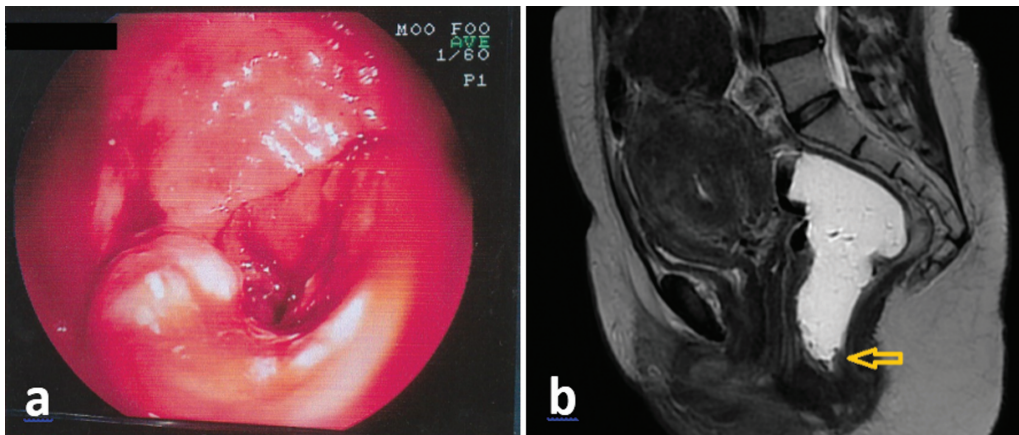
(a) Rectal tumor endoscopic view. (b) Magnetic resonance imaging view of the tumor.
